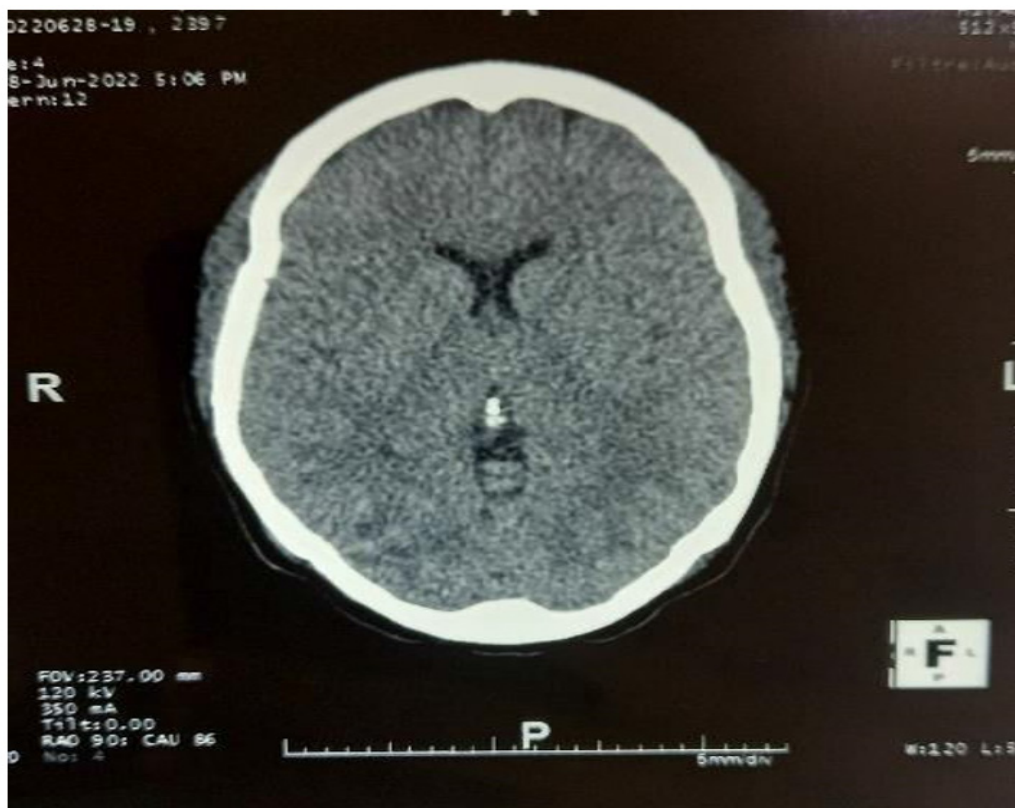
Control cerebral CT
